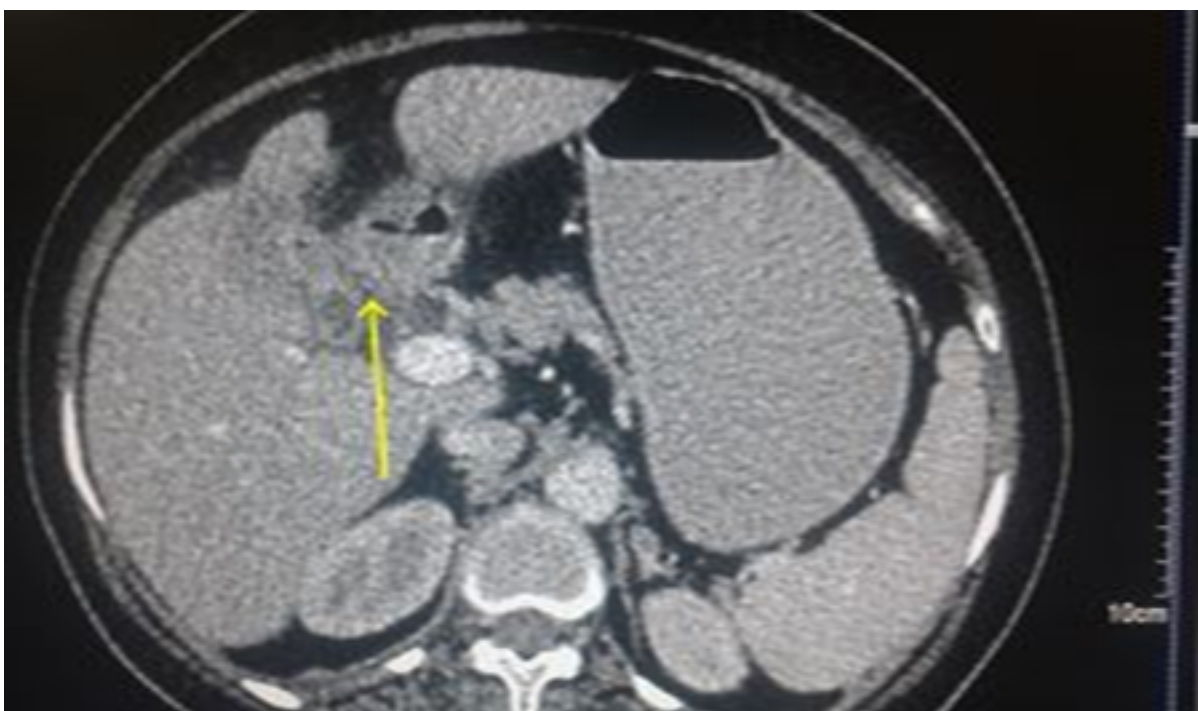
Axial section of contrast enhanced abdominal computed tomography shows collapsed Gall bladder showing loss of clear interface with adjacent duodenal loop
